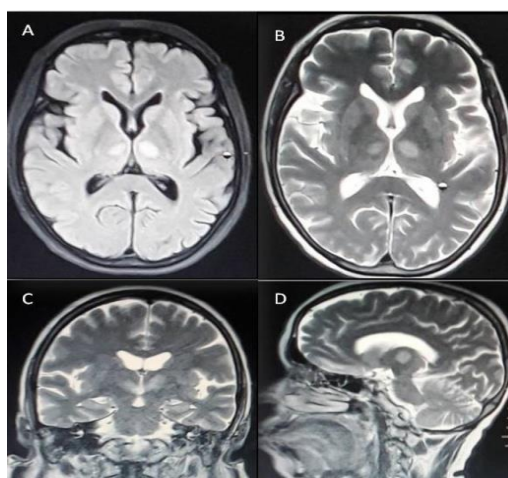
MRI axial section, FLAIR axial (A), T2 axial, coronal and sagittal section (B, C, D) shows high signals on the bilateral paramedian area of the thalamus
